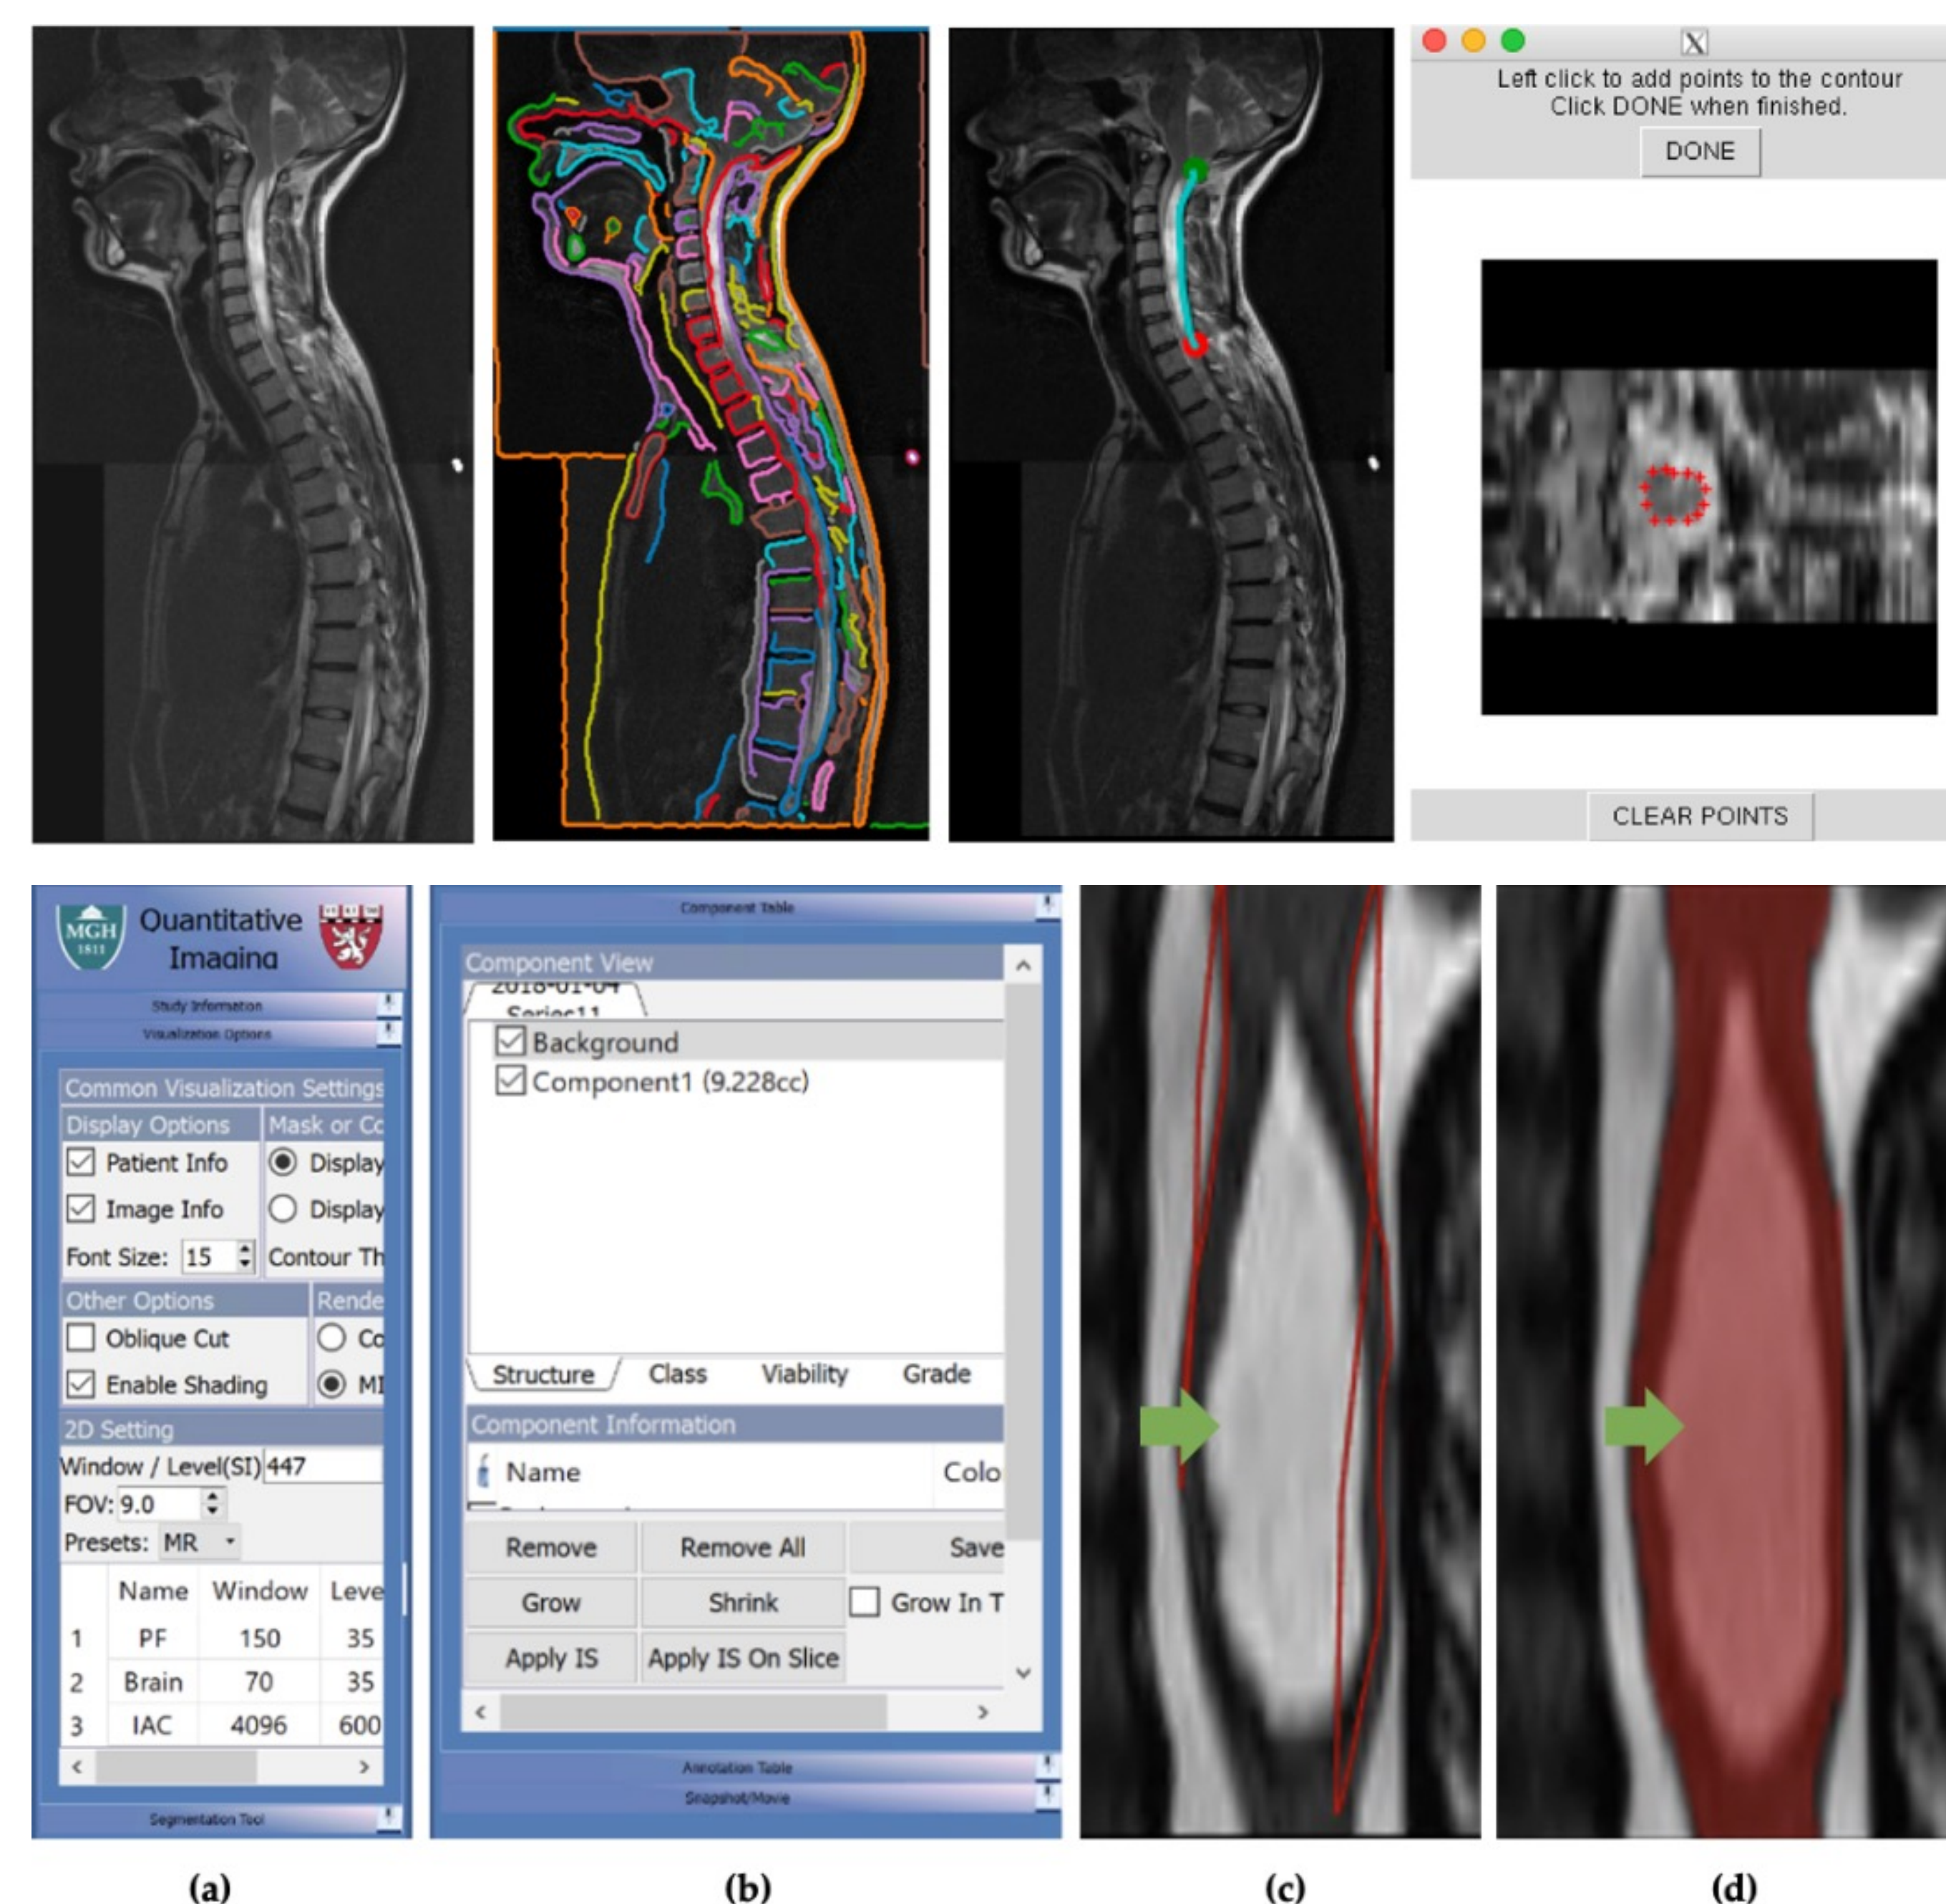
SCAT edge detection (top) and 3Dqi (bottom) were used to measure syrinx volume on T2-weighted axial MRI images.
